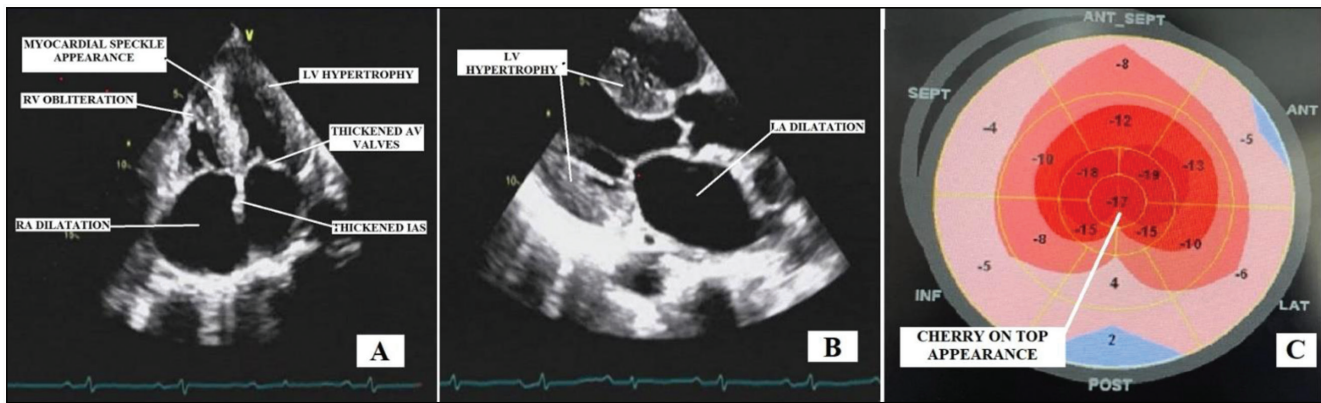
Two-dimensional trans-thoracic echocardiography (A) apical four-chamber view showing LVH, thickened IAS and AV valves, right atrial dilatation, and RV apical obliteration (single arrows). (B) Parasternal long axis view showing LVH (red arrow), LA dilatation. (C) Strain rate imaging of LV showing abnormal GLS with apical sparing—“Cherry on top” appearance. Abbreviations: LV: left ventricle, LA: left atrium, RA: right atrium, RV: right ventricle, IVS: interventricular septum, IAS: interatrial septum, AV: atrio-ventricular
